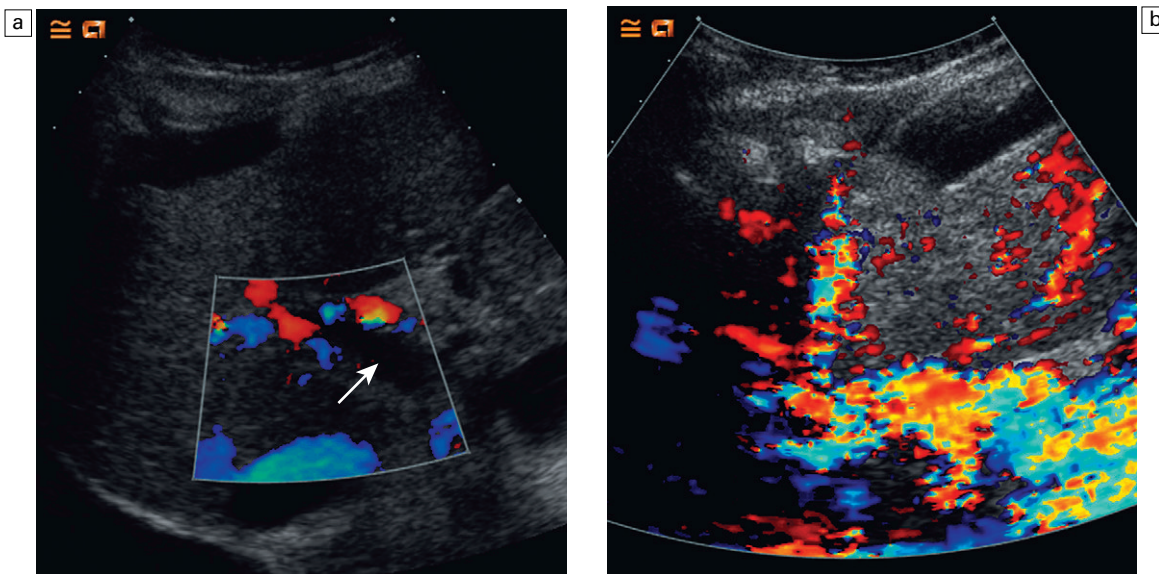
A commonly seen artefact when using microbubbles to enhance conventional Doppler studies is ‘blooming’ in which colour pixels appear to extend beyond the bounds of the vessel; (a) baseline colour Doppler image at the level of the porta hepatis demonstrating absence of colour signal in the portal vein (arrow) but colour is present in the overlying hepatic artery; (b) following the administration of SonoVue® ‘blooming’ from the hepatic artery obscures the portal vein.
